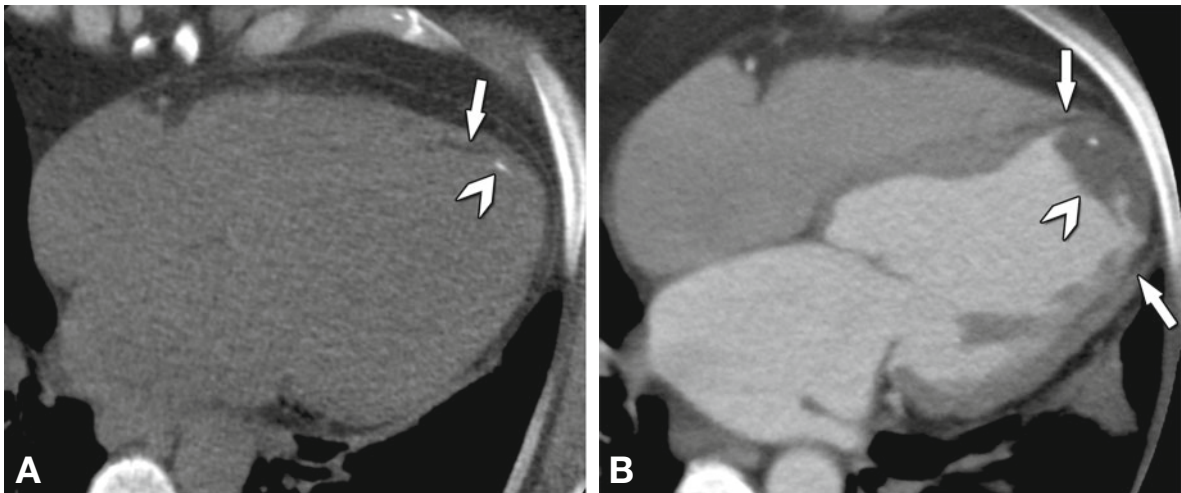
Chronic apical infarction seen on a noncontrast scan as an incidental finding in a 50-year-old female patient with a calcium score of zero. Panel A shows the apical infarction with thinning and fatty degeneration of the myocardium (arrow), while a nearby calcification is also visible on a four-chamber view reconstructed from the non-contrast acquisition (arrowhead). Panel B shows a 5-mm average reconstruction in the four-chamber view from contrast-enhanced CT angiography in the same patient, delineating the thinned fatty myocardium (arrows) and an apical thrombus (arrowhead) that contains the calcification
